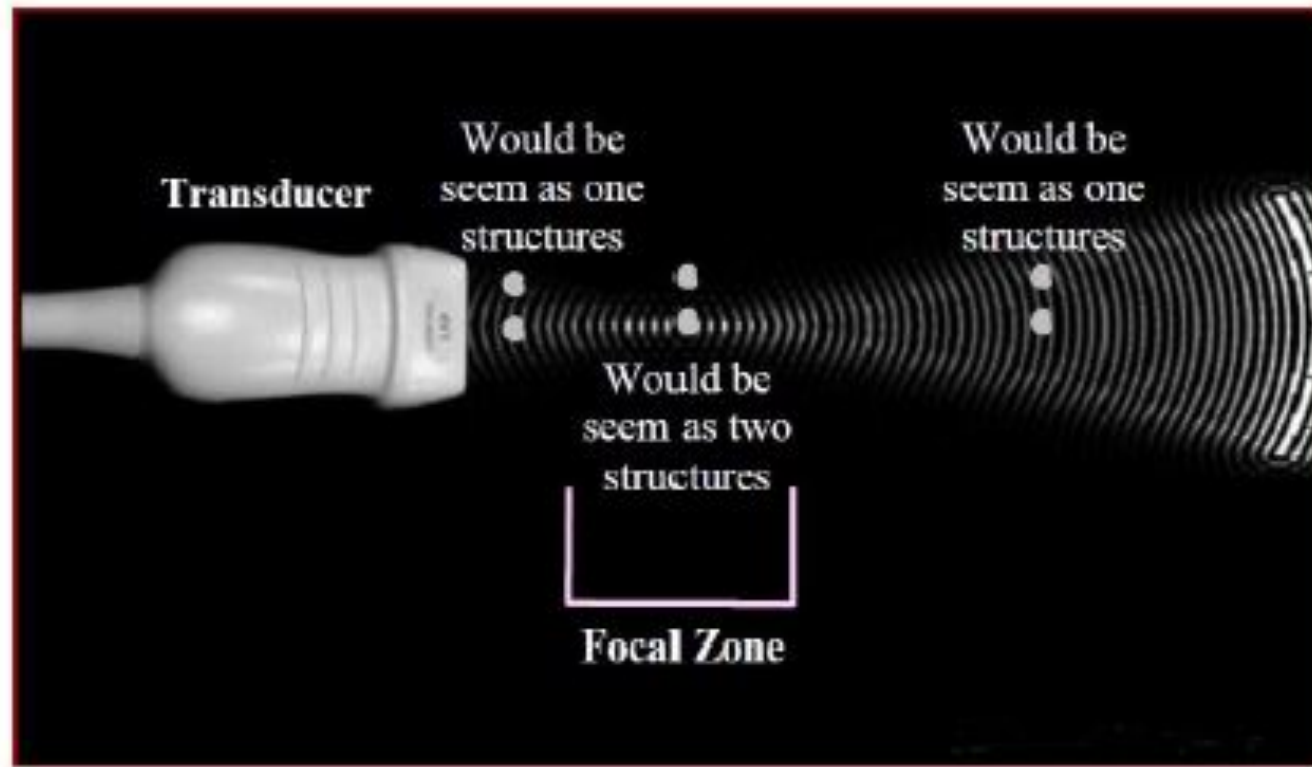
Lateral Resolution is the minimum separation from other tissue the ultrasound beam can distinguish in a plane perpendicular to the ultrasound beam.
